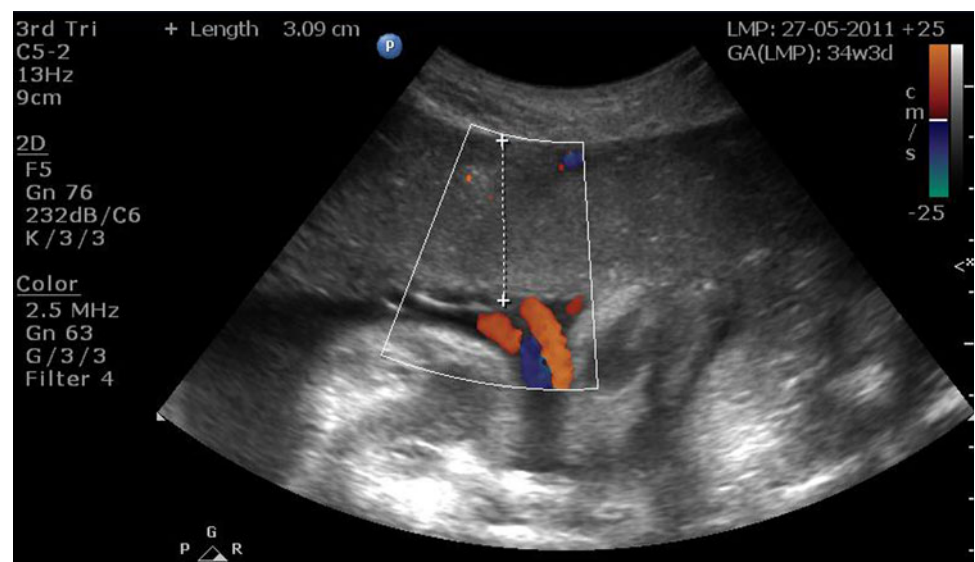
Ultrasound image in another patient showing the placental thickness at the cord insertion site
